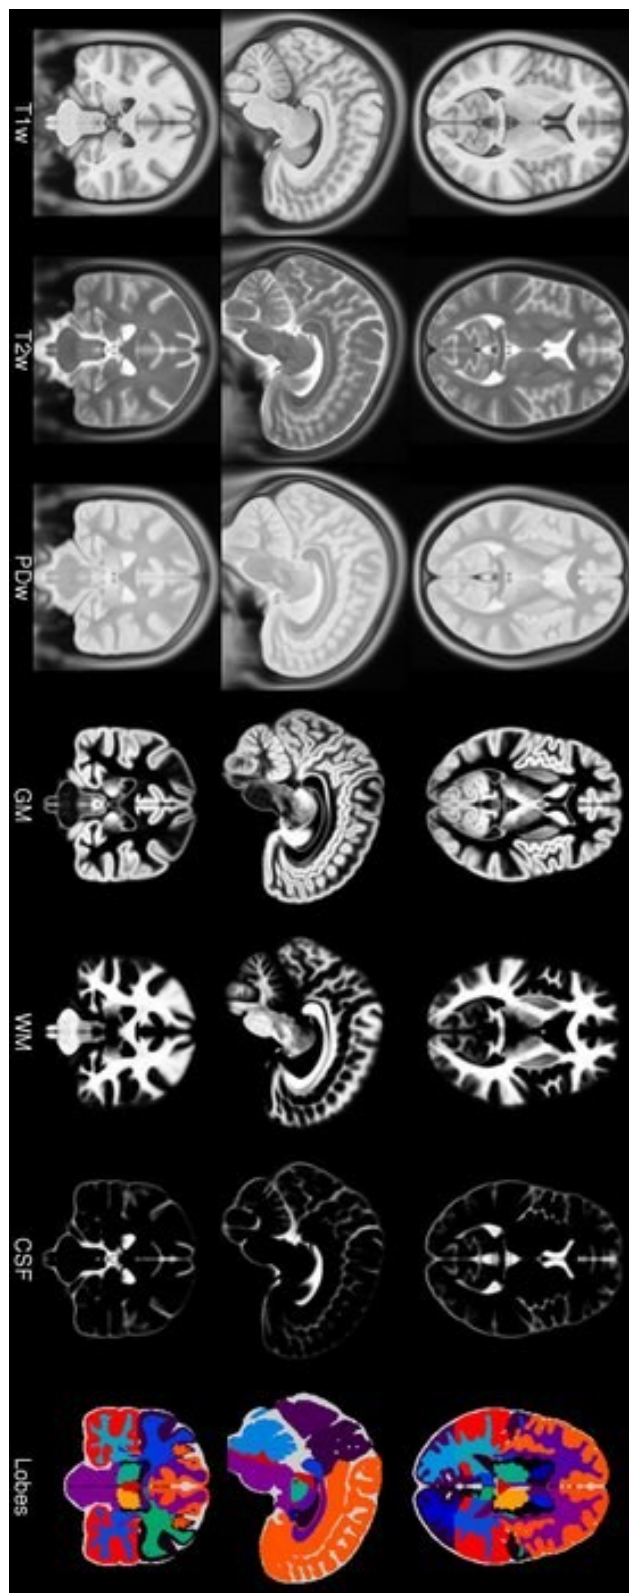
ICBM152 2009c Nonlinear Symmetric atlas[131]. From left to right, average-intensity MRI images for T1 T2 and PD weighted MRI scans, tissue probability maps for gray matter, white matter and CSF, and region distribution maps are shown in this figure.
